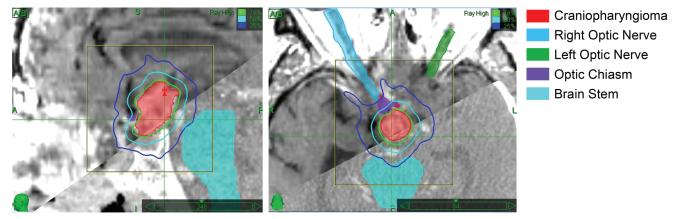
Sagittal (left) and axial (right) CT/MR fusion planning images. Left: Area of targeted therapy and isodose lines are demonstrated. Right: Area of suspected tumor with regions of anatomical importance, including right optic nerves and brainstem, are shown.
